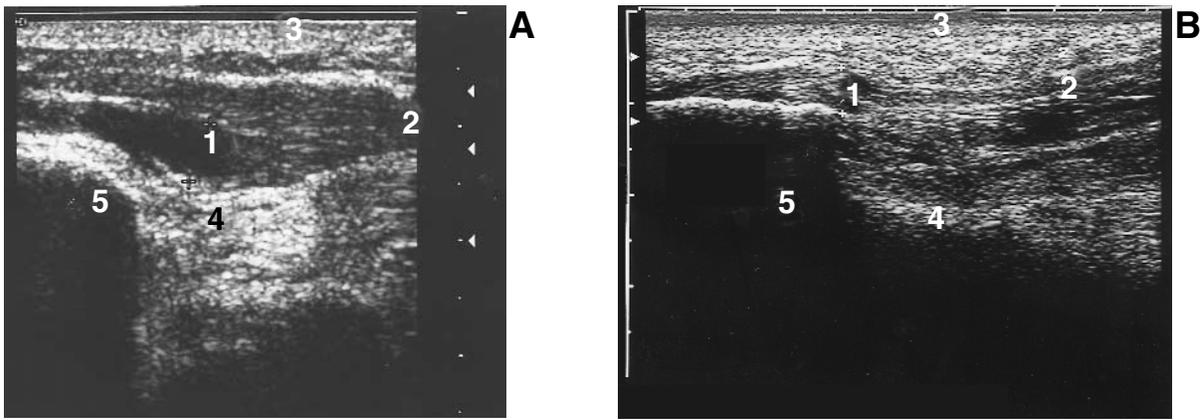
Longitudinal sonograms of symptomatic (A) and asymptomatic (B) plantar fascia. A, The symptomatic plantar fascia is shown as a black thickened space (area 1) with decreased echogenicity. The distal plantar fascia is less thickened and less symptomatic (area 2). Skin and subcutaneous tissue (area 3) and tissue deep to the plantar fascia (area 4) are represented by white stippling. Acoustic shadowing of the calcaneus is blackened (area 5). B, The asymptomatic plantar fascia is shown by fine blackened parallel echogenic lines with slight variation in thickness or echogenicity (areas 1 and 2). Skin and subcutaneous tissue (area 3) and tissue deep to the plantar fascia (area 4) are represented by white stippling. Acoustic shadowing of the calcaneus is blackened (area 5).
